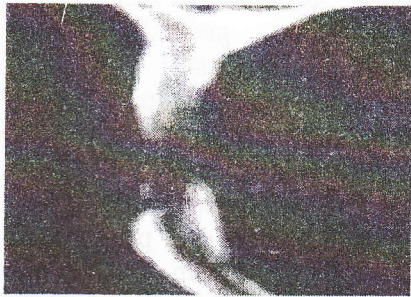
Lateral X-Ray of cervical spines, multi-level laminectomy.
